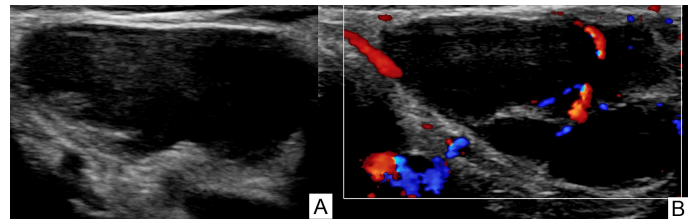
Cervical lymphadenopathies.(A) Both hilar and peripheral vascularization are present in the color Doppler ultrasonographic image (B).
